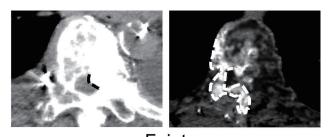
Images and medical records were evaluated by two experienced radiologists (with 15 and 7 years of radiological diagnostic experience), who assessed and scored the clarity of the boundary between the normal bone and tumor depicted by s-CTA or ns-CTA. The clarity score, which was based on a scoring system for arterial invasion of pancreatic body and tail cancer,¹⁵ was divided into four grades: good (all boundaries between normal bone and tumor could be traced, 3 points), fair (more than half of the boundaries between normal bone and tumor could be traced, 2 points), faint (less than half of the boundaries between normal bone and tumor could be traced, 1 point), and poor (none of the boundaries between normal bone) (Fig. 2).
